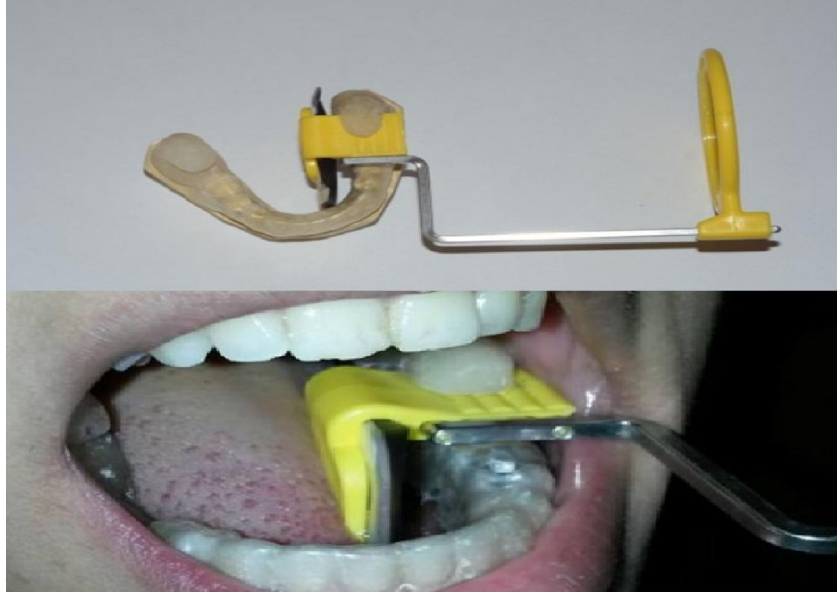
The radiographic stent used for standardized Intraoral digital radiographs
